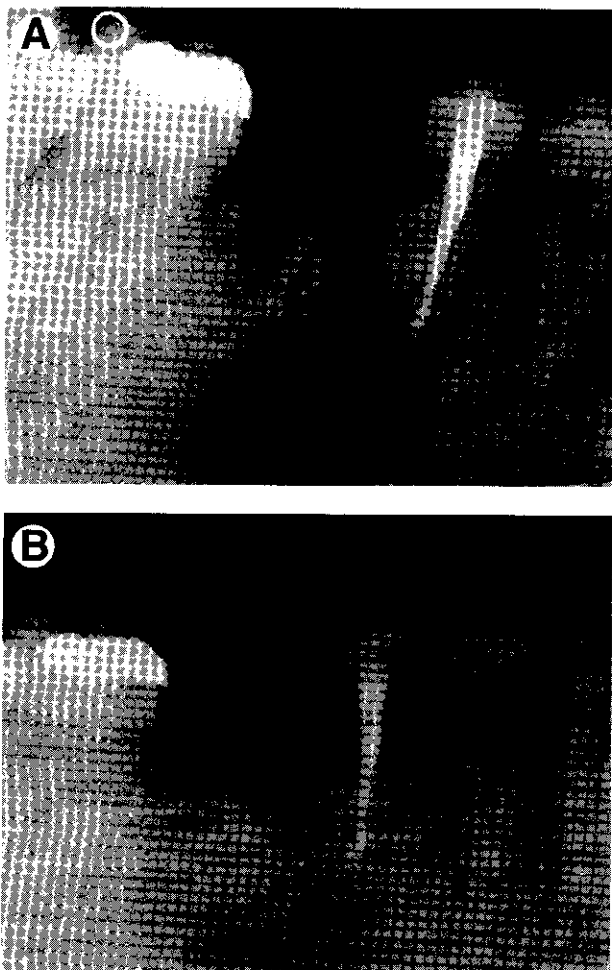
A large periapical lesion treated without guided tissue regeneration. A, Radiograph soon after surgery. B, The same lesion 1 year after surgery, classified as success. Radiographically, the bicuspid shows a periapical lesion that could appear to be contiguous with the lesion of the molar. However, during surgery and after molar removal, the 2 lesions appeared to be separate entities with no communication. The 2 areas of radiolucency were located on different planes. We assumed that bone healing of the bicuspid was not affected by molar removal and by the healing process that occurred at the level of the molar itself.
